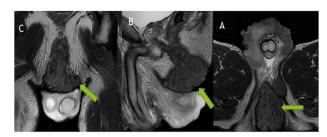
MRI of the penis (A: Axial T2 sequence, B: Sagittal T2, C: Coronal T2) revealing a perineal mass with hypo-intense T2 signal, infiltrating the internal and external sphincters, extending down to the scrotum.
